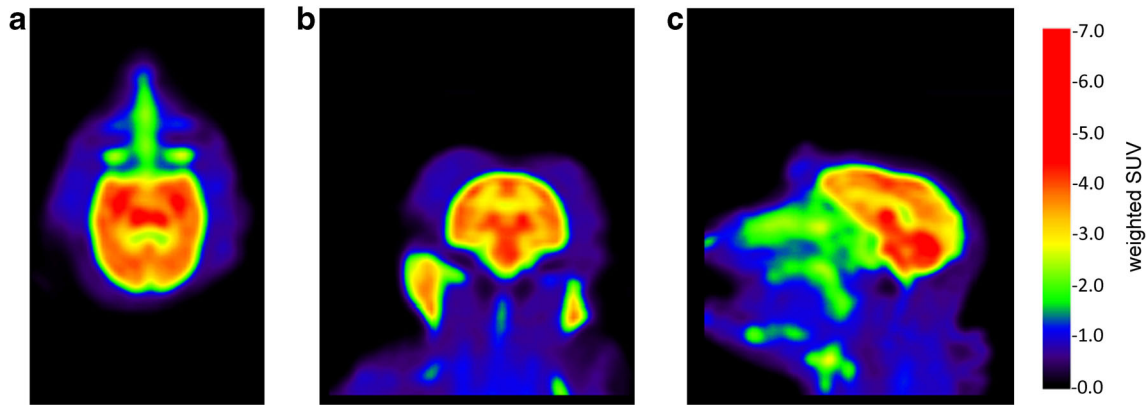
a Transaxial, b coronal and c sagittal views of time-weighted SUV PET images from 0 to 90 min.
